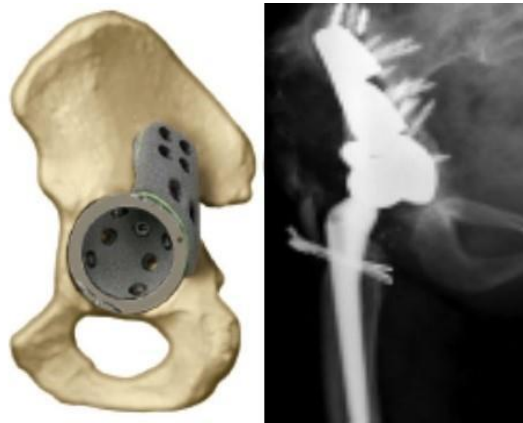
Buttress augments for column defects. Algorithmic and postoperative X-ray ⁽⁷⁴⁾.
